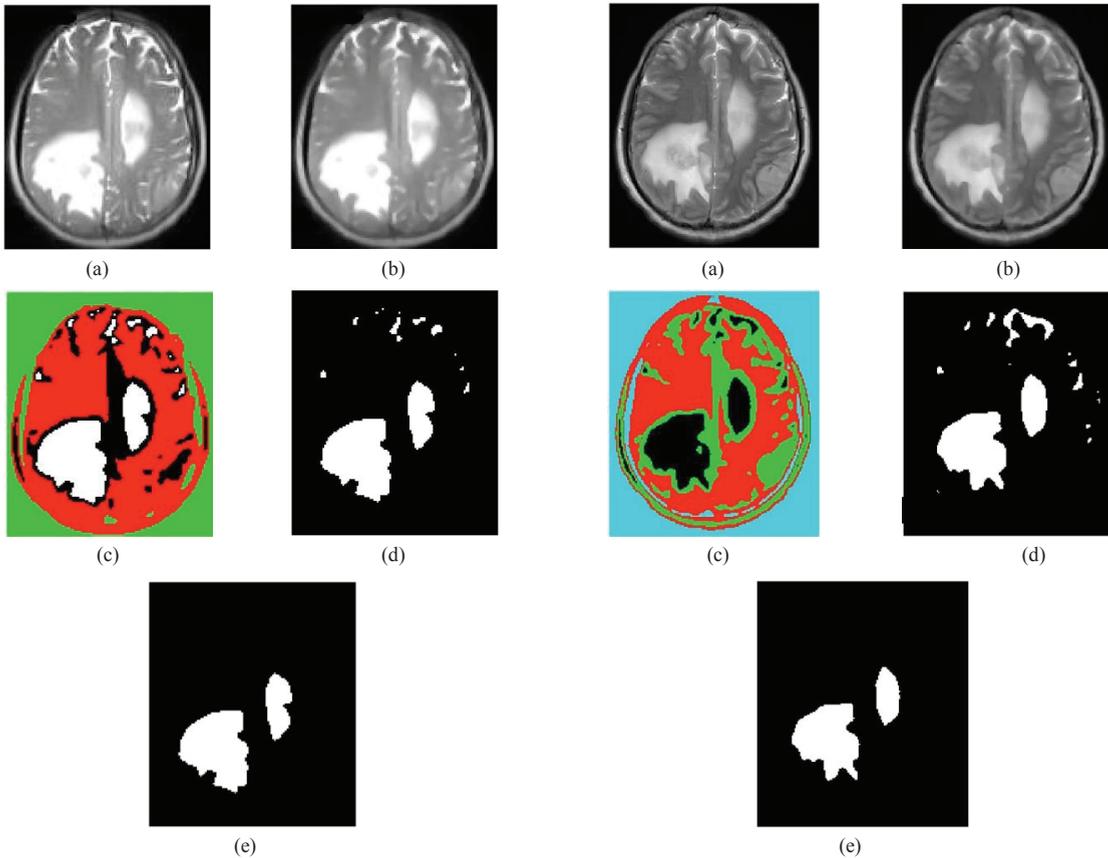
(a) T1 brain MRI; (b) Pre-processed MRI; (c) Clusters; (d) RI validation; (e) Post-processed Image
